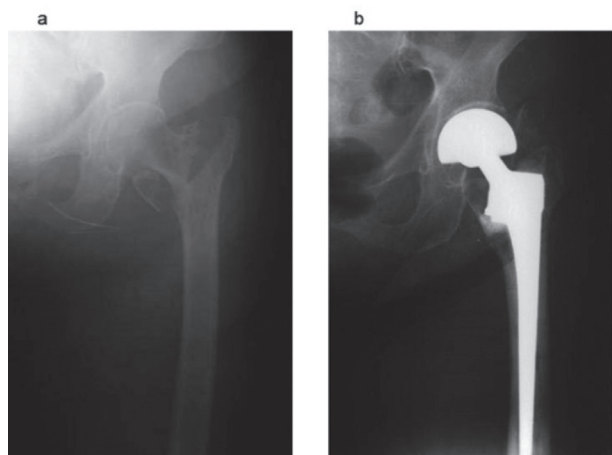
Radiographic images of an 86-year-old female treated using partial bipolar calcar replacement endoprosthesis (a) preoperative, (b) postoperative
